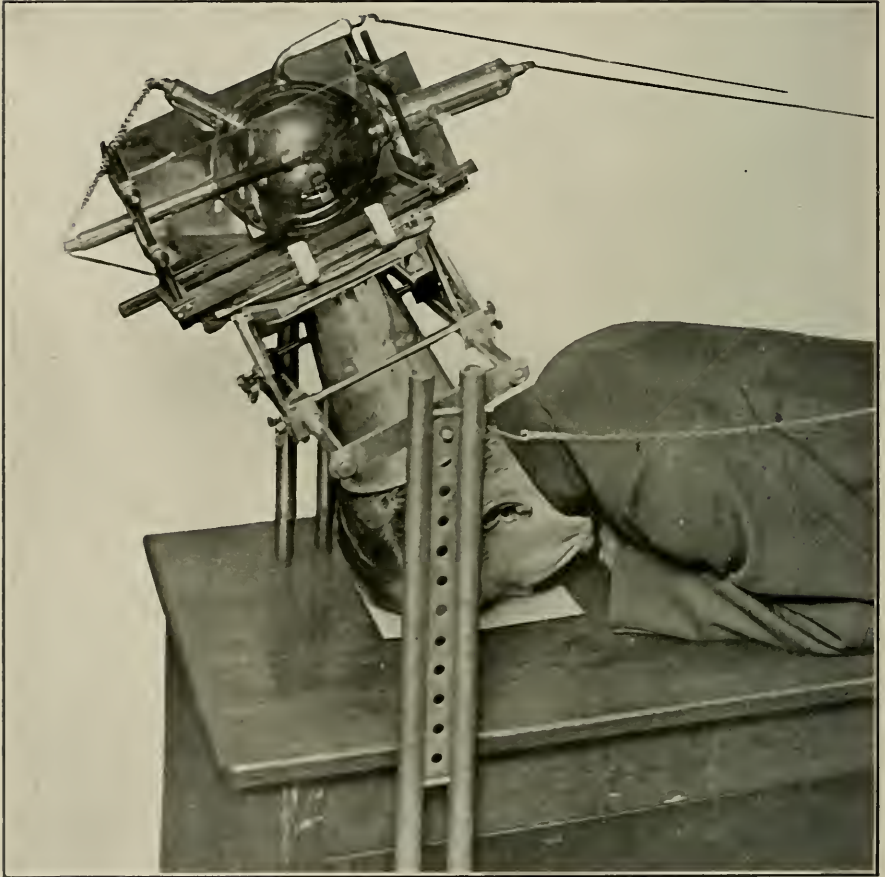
Pose for making radiograph of the antra of Highmore.
